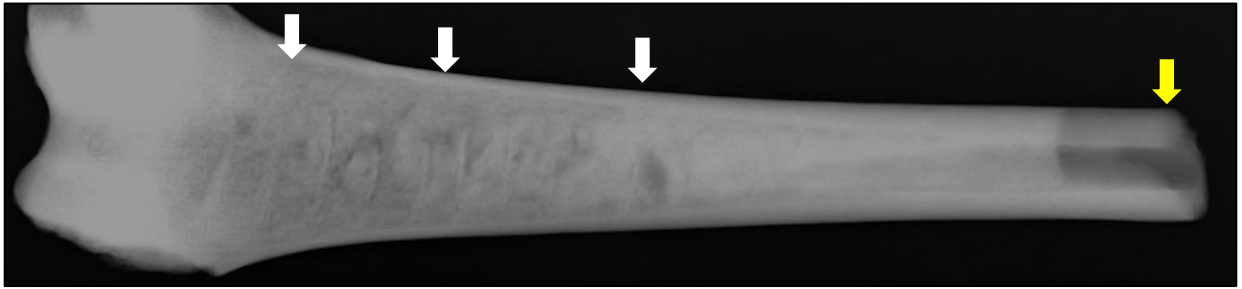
Radiographic lesions suggestive of possible thalassemia in CCN13M113a, middle aged adult male. Note the widespread ischemic necrosis (white arrows), and the “double cortex” sign (yellow arrow).
